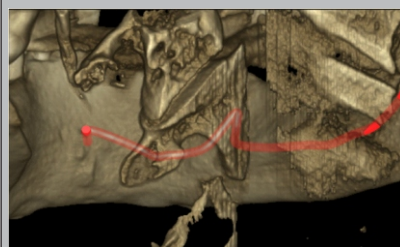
3D tracing the point of entry of the sublingual artery to the mandible using CBCT.
